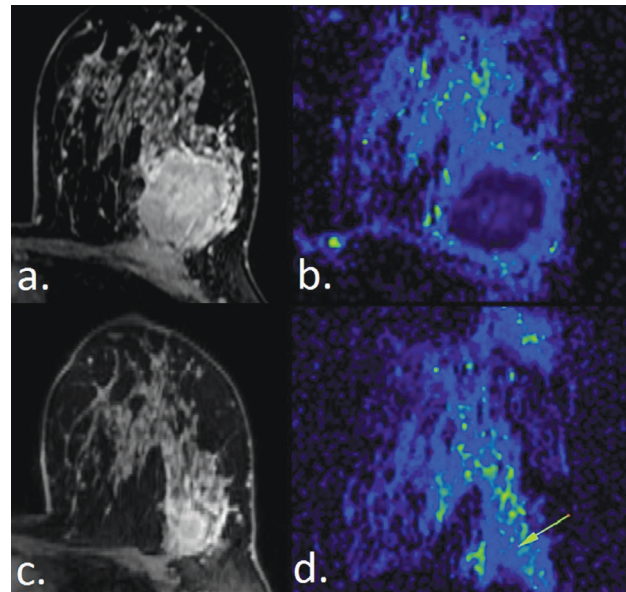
TN, G3 IDC at baseline (a. CE-MRI, b. ADC map) and after 6 NAC cycles (c. CE-MRI, d. ADC map). Comparison of the CE images suggests a partial response. However, on the post-treatment ADC map, no areas of restricted diffusion are identified (arrow), thus indicating a complete response. Pathology confirmed complete response, with lack of an invasive tumour
